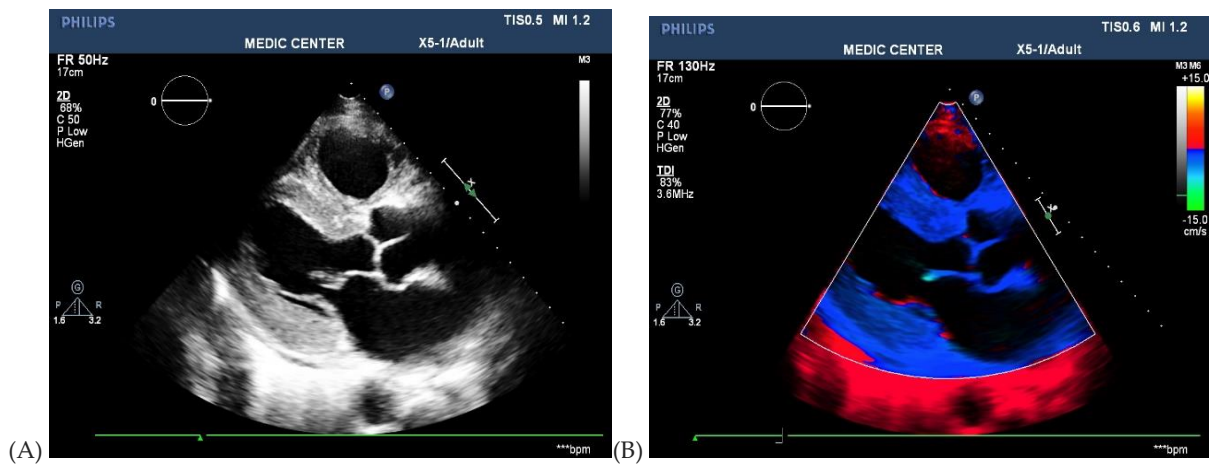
A: Parasternal LAX view visualized sparkling sign and a small pericardial effusion. B: The same image with Tissue Doppler Imaging, Sparkling sign still was visible.
